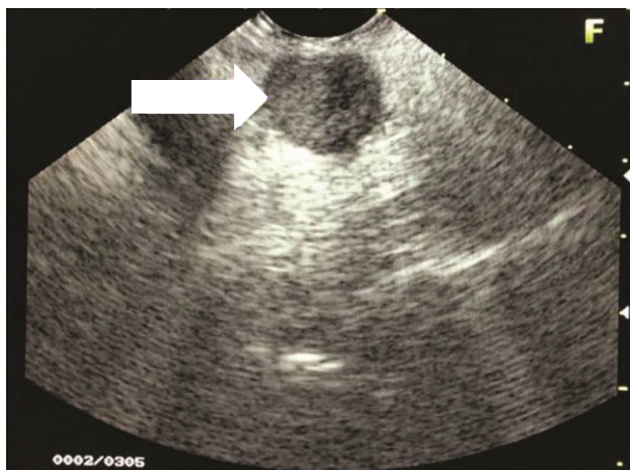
Endoscopic ultrasound shows a 1.5 x 2.0 cm hypoechoic to isoechoic mass at the head of the pancreas.
